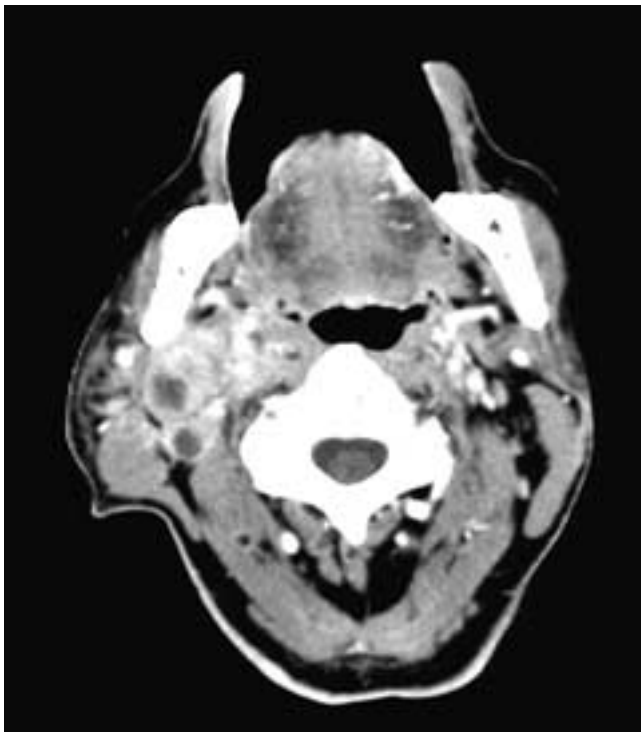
Axial contrast-enhanced CT scan shows two necrotic right level II nodes. Each enhancing nodal capsule is of uneven thickness, and there is extracapsular tumor spread, as noted by infiltration of the adjacent fat planes. Also note that the carotid artery is surrounded by tumor, making it likely that the arterial wall has been invaded by tumor.
